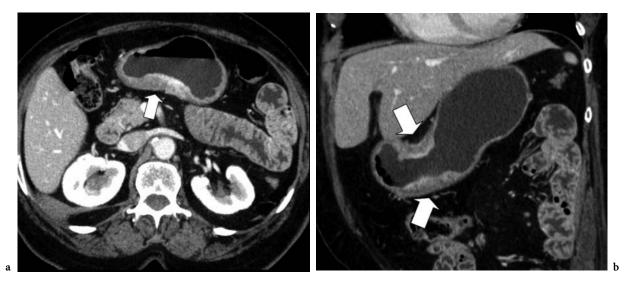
a Enhanced axial CT using water as oral contrast material shows markedly distended stomach with a circumferential mass (*arrow*) located at gastric angulus. b Coronal oblique view clearly demonstrate the overall length of the neoplastic lesion (*arrows*) and its relationship with gastric wall and perigastric fat tissue not involved by the tumor
